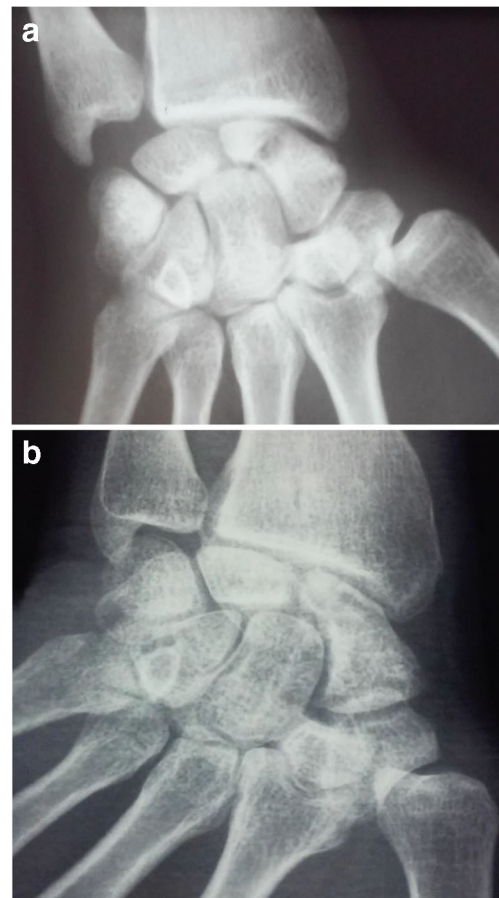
a Pre-operative radiograph SNU treated with vascularized bone graft. b Postoperative radiograph SNU treated with vascularized bone graft
